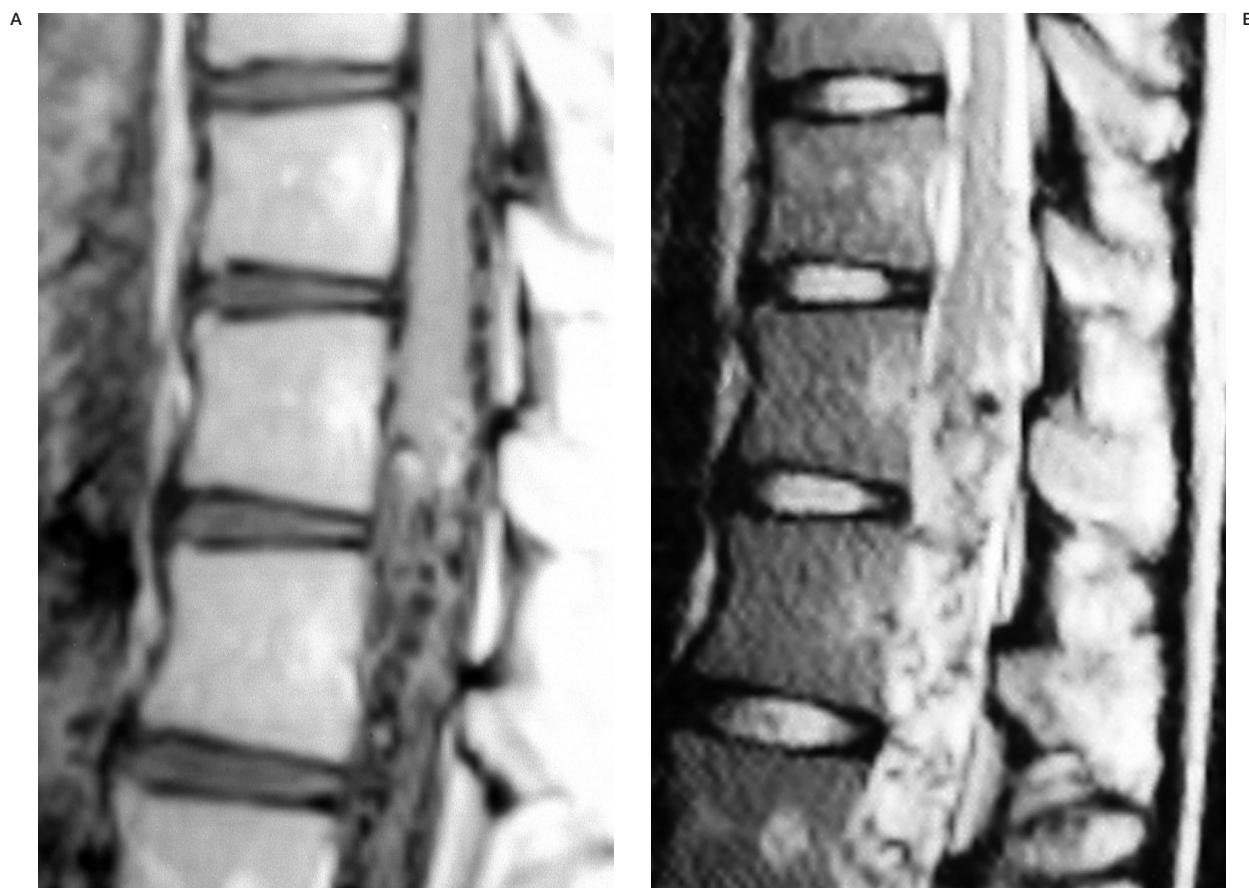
A) MRI T1WI with Gd in sagittal view demonstrates gadolinium enhanced vascular lesions around conus medullaris. B) MRI T2WI in sagittal view demonstrates vascular flow void around conus medullaris.
